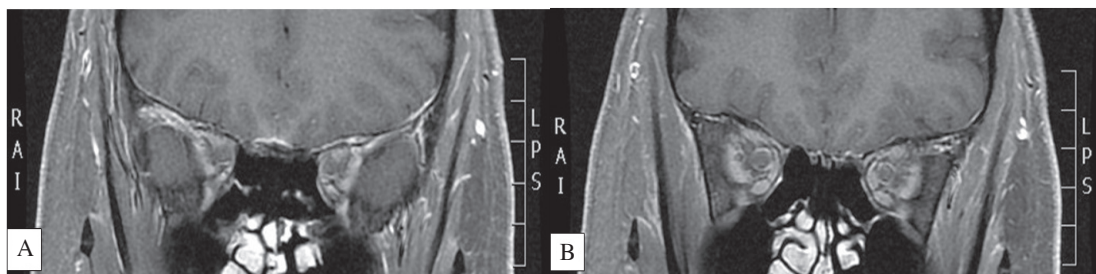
MRI performed 3 months following spontaneous resolution of symptoms. (A) and (B): MR coronal T1 weighted imaging post gadolinium with fat suppression demonstrates an improvement of the enhancing lesion in the left orbital apex.
